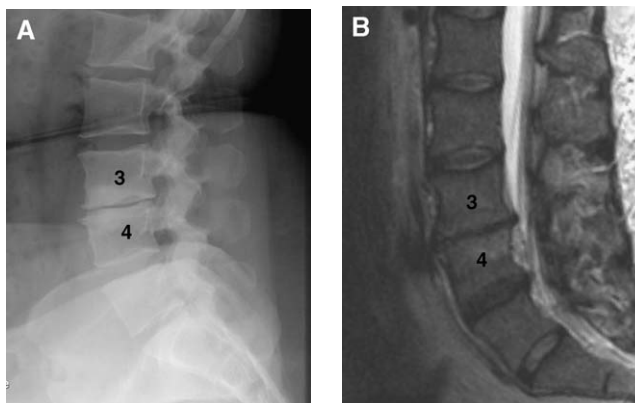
Lateral radiograph (A) and T2-weighted MRI (B) of an individual with intervertebral disc space collapse, end plate sclerosis, and osteophytes between the third and fourth lumbar vertebrae.
